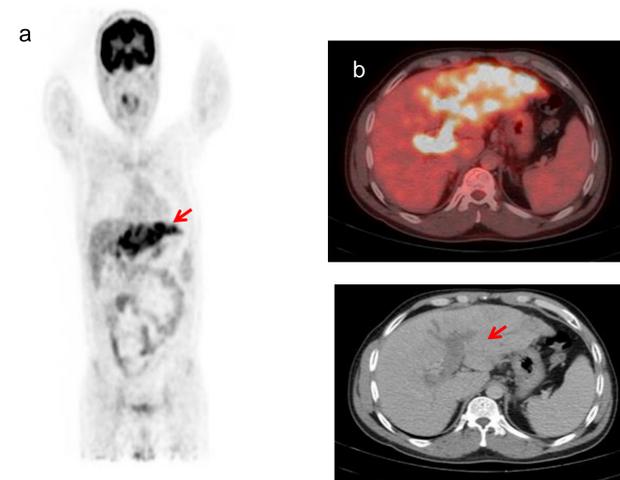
Restaging scan of a 42 year old male, showing diffuse tumour involving entire lobe in PET only image (a), with FDG-avid tumor thrombus in entire portal vein shown in fused axial (b) and CT only (c) images.
